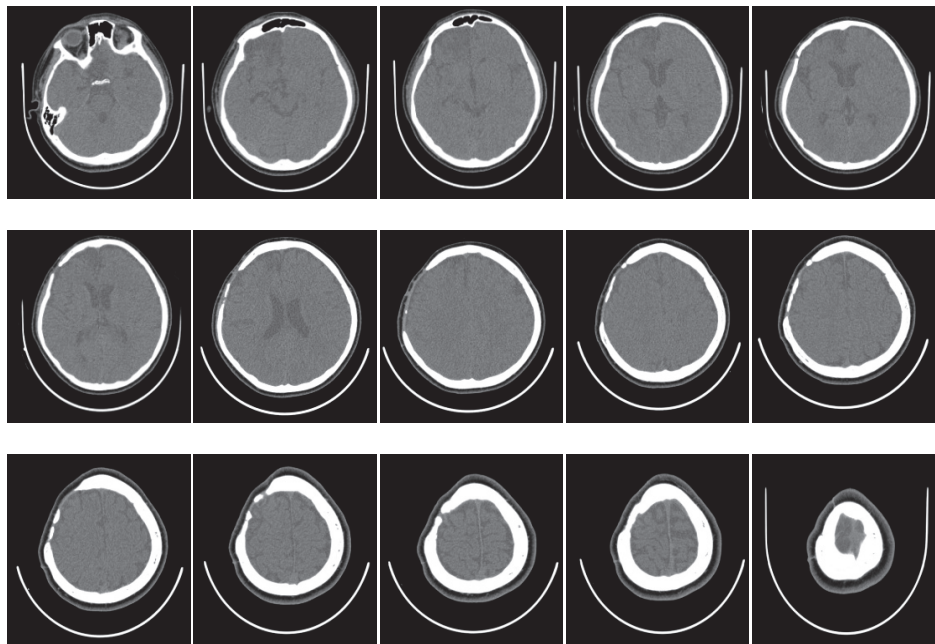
CT scan images of patient with left side parietal bone fracture
